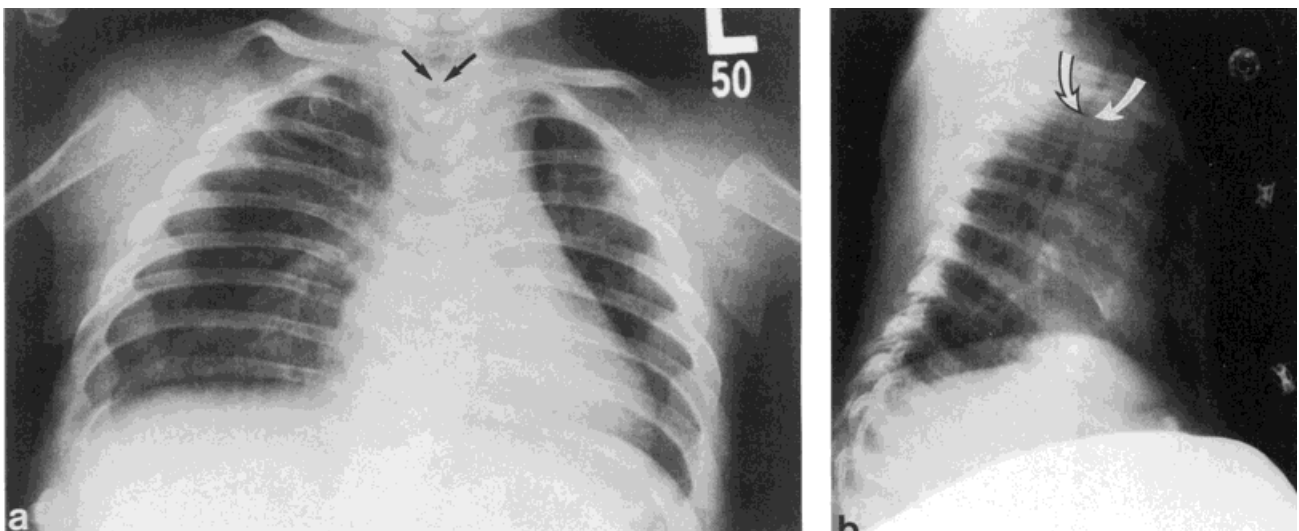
Patient 2, at 4 months. Frontal (left) and lateral (right) chest radiographs. The vertebrae are flattened, the pedicles are not visualized, and the posterior neural arches are unfused (arrows). The sternum is unossified. Scapulae are hypoplastic. The intrathoracic airway is narrowed (curved arrows).
